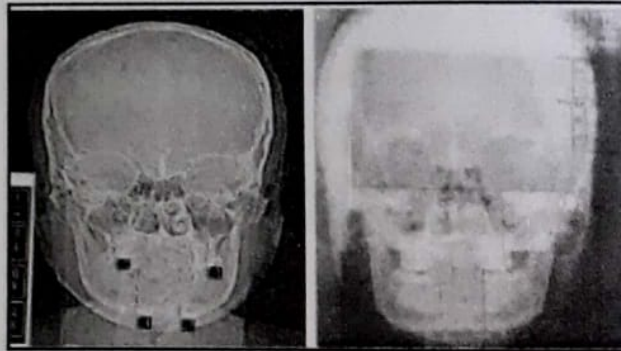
Measurement of maxillary height in CT and PA ceph.
